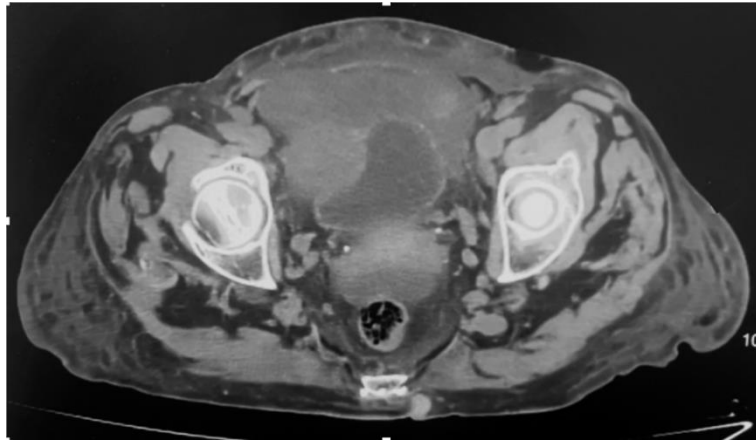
Axial pelvic CT showing a well-defined right latero-uterine cystic mass, suspicious for an ovarian neoplasm
